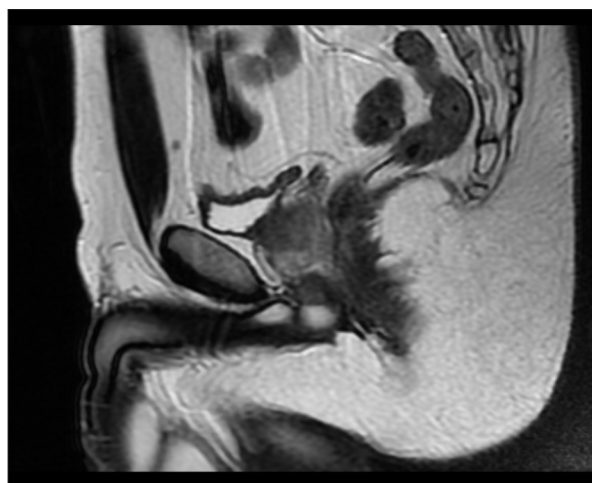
Pelvic magnetic resonance imaging (MRI). Pelvic MRI performed for staging demonstrated no evidence of pelvic tumor extension, enlarged pelvic lymph nodes, or metastatic disease.
